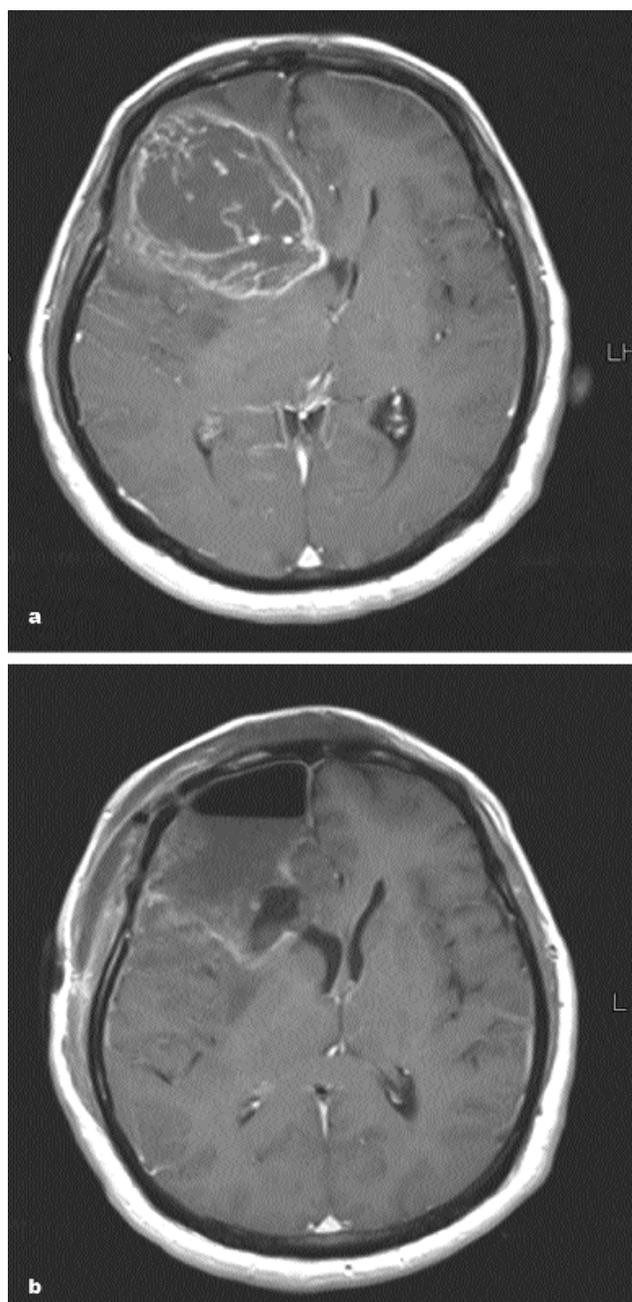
a) Pre-operative MRI T1WI with contrast showing the typical location of a GBM with IDH1 mutation. b) Post-operative MRI T1WI with contrast of the same patient showing gross total resection.
